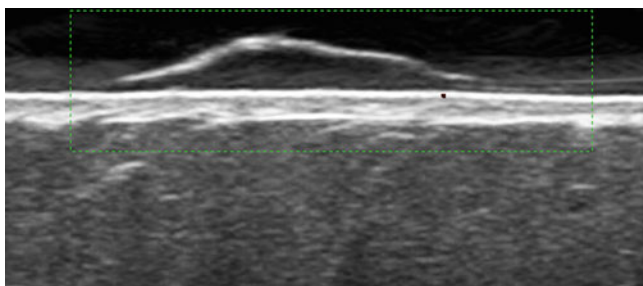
Primary melanoma of the forearm. Image taken with a gel pad spacer. Directional power Doppler scan. The raised melanoma lesion shows no substantial flow signals internally
